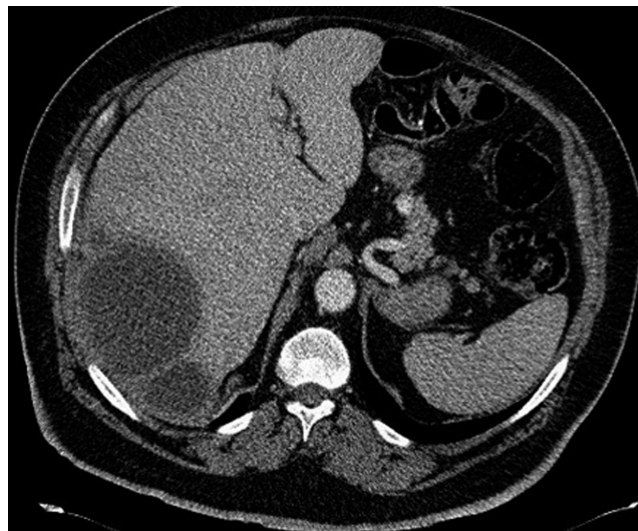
Abdominal CT scan with contrast. Note the subcapsular right posterior loculated fluid collection.
